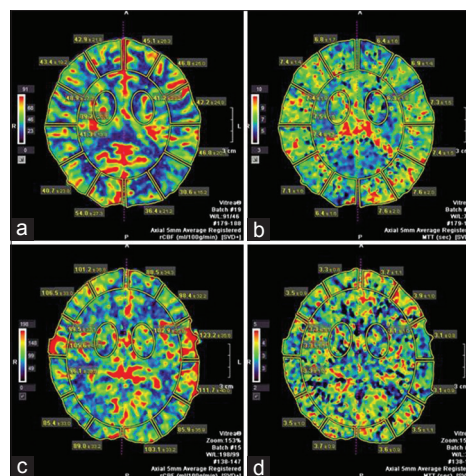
Perfusion computed tomography (CT) images the same patient. Preoperative perfusion CT images and quantitative parameters showed diminished cerebral blood flow (CBF) (a) and prolonged mean transit time (MTT) (b) on both hemispheres, consistent with perfusion deficit due to moyamoya disease. Postoperative perfusion CT demonstrates a significant increase in CBF (c) and a significant decrease in MTT (d) on both hemispheres at the 3rd month after bypass
